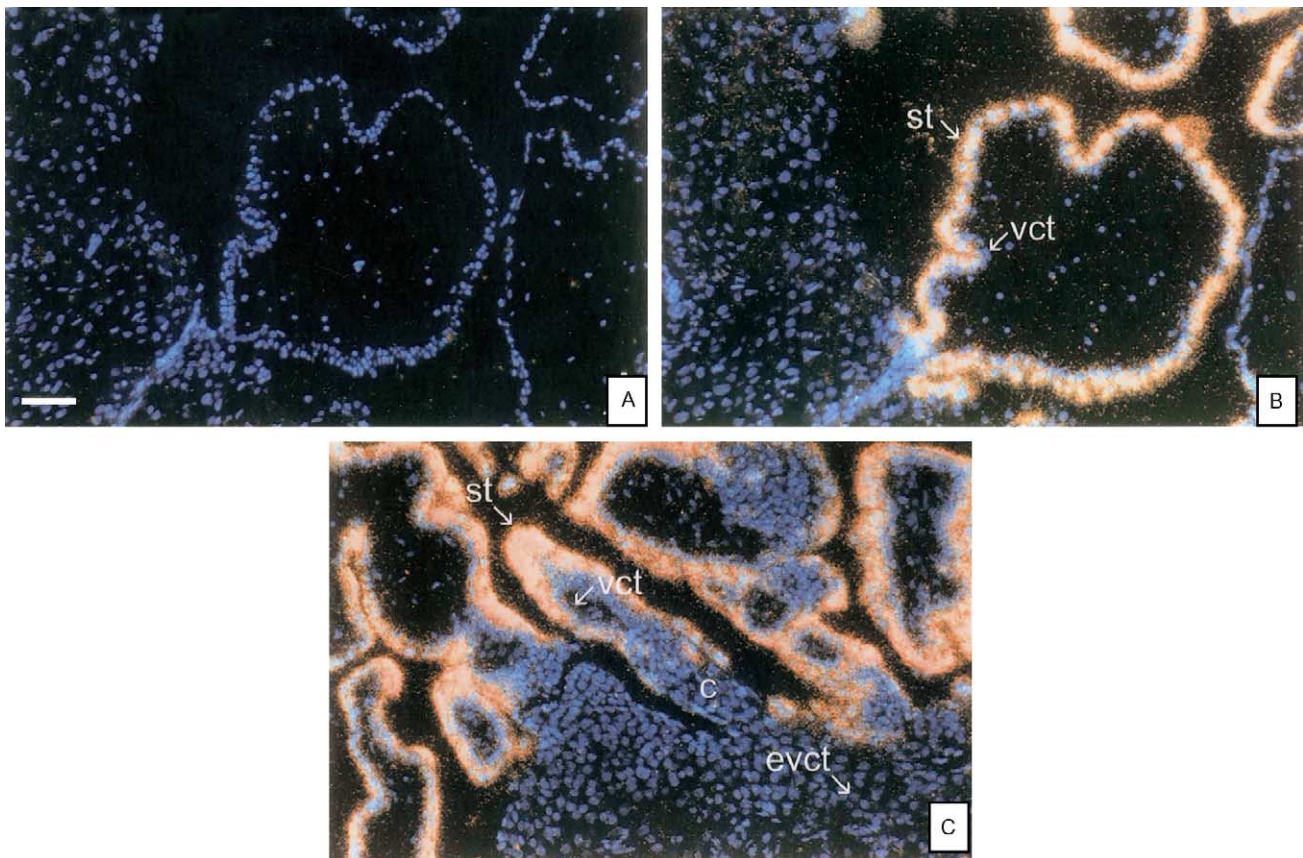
Expression of P450arom mRNA at the fetal–maternal interface during tubal pregnancy was analyzed by in situ hybridization. (A) Negative control using a sense probe. (B and C) Detection of P450arom mRNA in ST, VCT, column CT and EVCT cells using an antisense probe. The column is represented by c (in C), and the magnification is 100× (scale bar shown in A = 100 μm).
